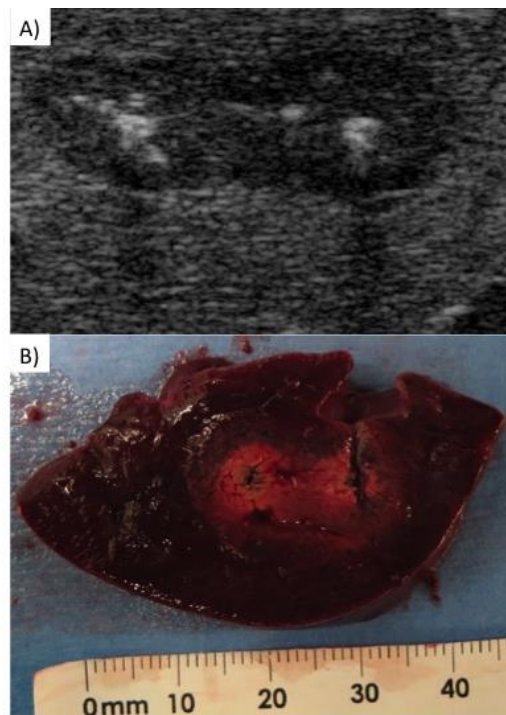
(A) ultrasound imaging immediately following treatment with 1800V/cm, 200 pulses, 200 us on time. Lesion is easily visualized immediately following treatment (hypoechoic area). The same “peanut” shape attributed to the H-FIRE treatment can be visualized 6 h after treatment using TTC confirming the shape seen in the ultrasound image
